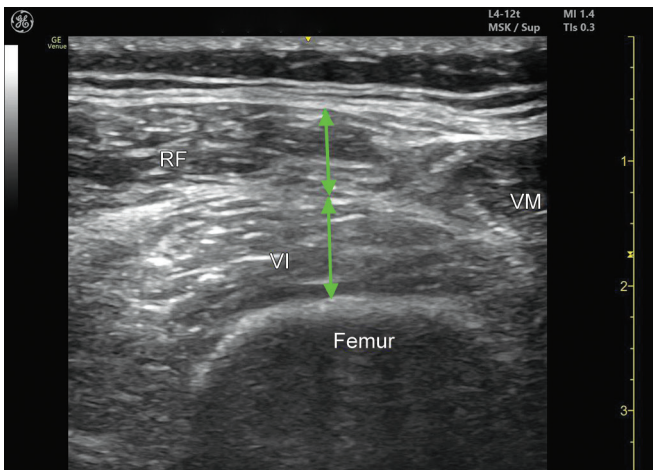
Assessment of quadriceps muscle thickness (RF, rectus femoris plus; VI, vastus intermedius; VM, vastus medialis) using ultrasound
